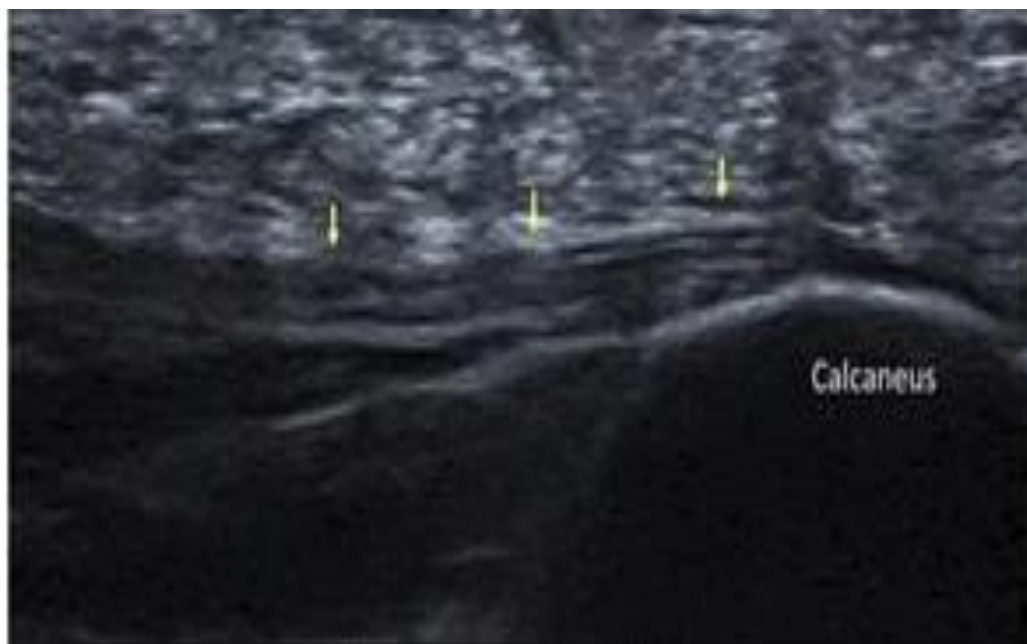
Normal plantar fascia on a sagittal ultrasound scan. Image adapted from a study by Draghi et al, 2017 on Imaging of plantar fascia disorders (11)
